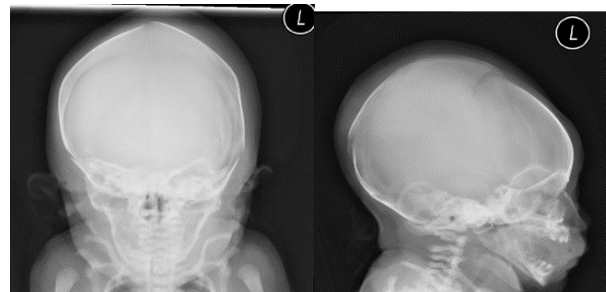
Anteroposterior skull and lateral skull x-rays showing opacities exterior to the skull at the parieto-occipital region
